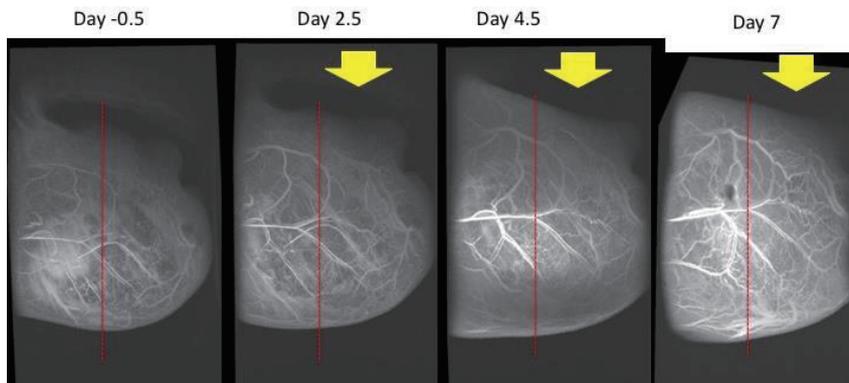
MRI images of partial irradiated tumor.
